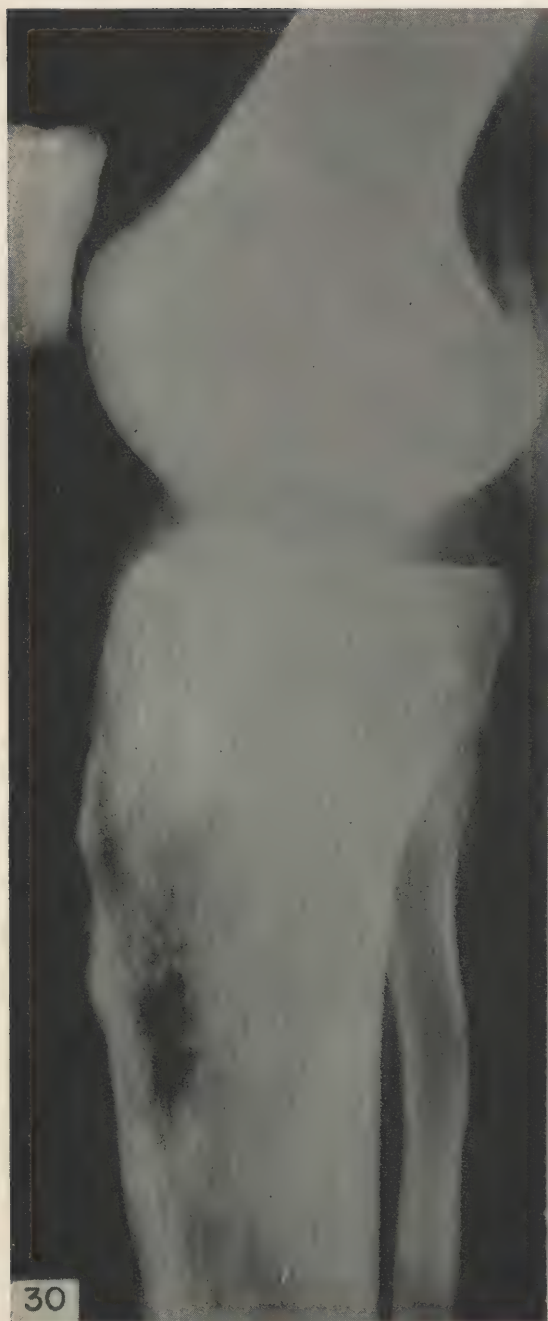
Disseminated coccidioidomycosis, AIP Ac. 78078: Roentgenogram of lesion of tibia. The bone destruction is more pronounced in the medullary portion, but also involves the cortex. Note also the fuzzy appearance of portions of periosteum. Death in 140 days.
